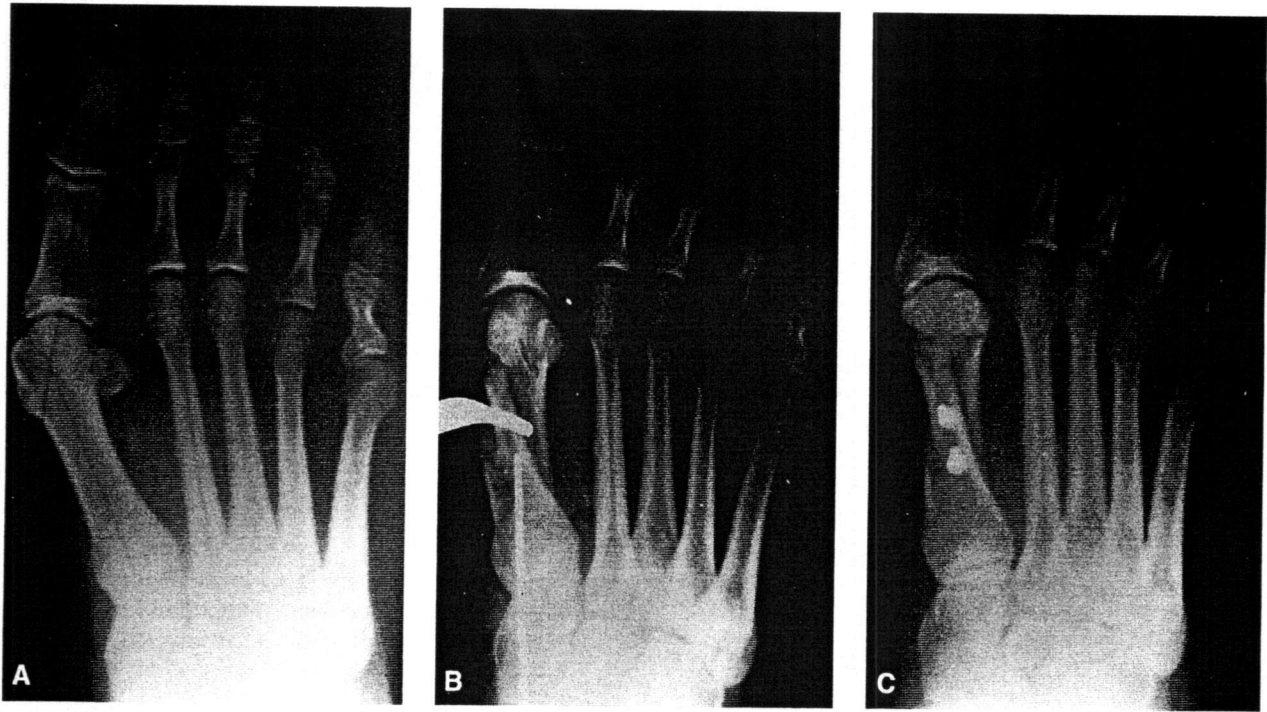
A: Preoperative radiograph of a patient with hallux abducto valgus deformity. B: Intraoperative radiograph after the Mau osteotomy. Note the Kirschner wire, used as an axis for rotation. C: The osteotomy after fixation.
